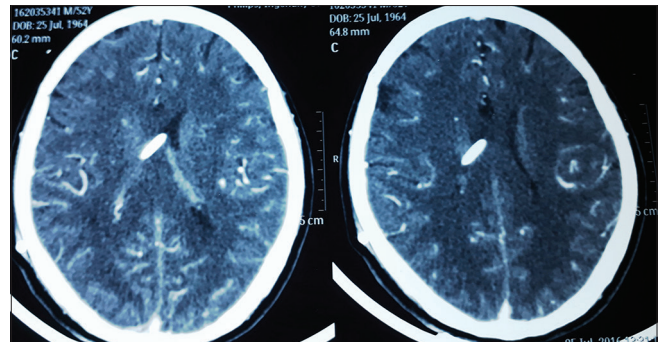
Contrast-enhanced computed tomography after shunt surgery, ventricles has returned to normal size
